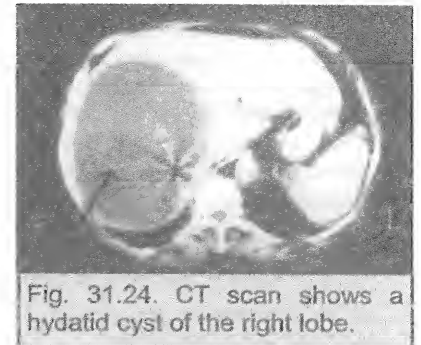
CT scan shows a hydatid cyst of the right lobe.
